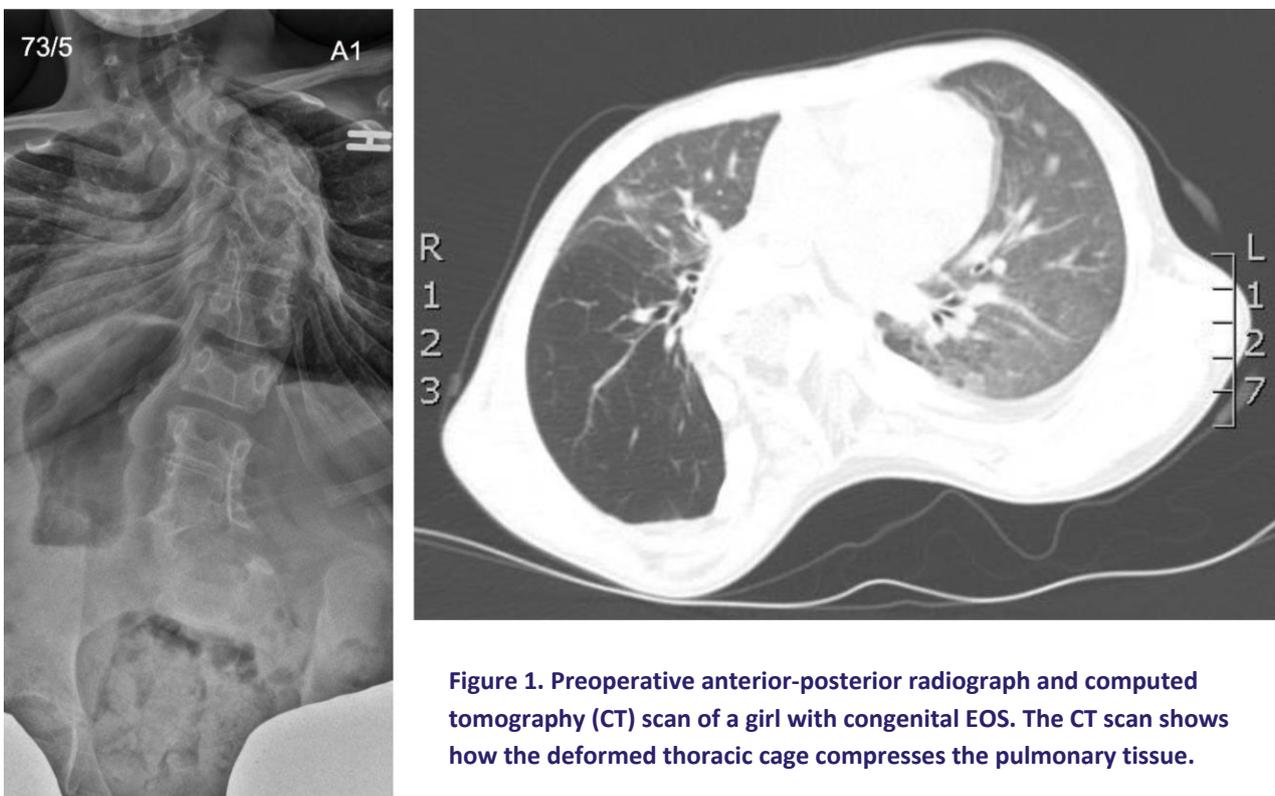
Preoperative anterior-posterior radiograph and computed tomography (CT) scan of a girl with congenital EOS. The CT scan shows how the deformed thoracic cage compresses the pulmonary tissue.
